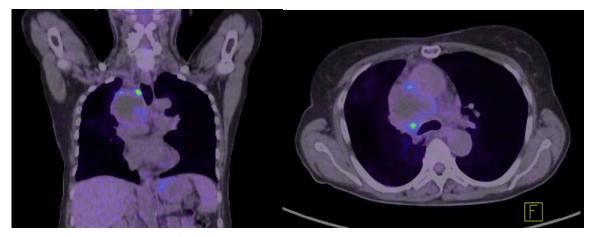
¹⁸FDG-PET-CT images after the successful KRT.
